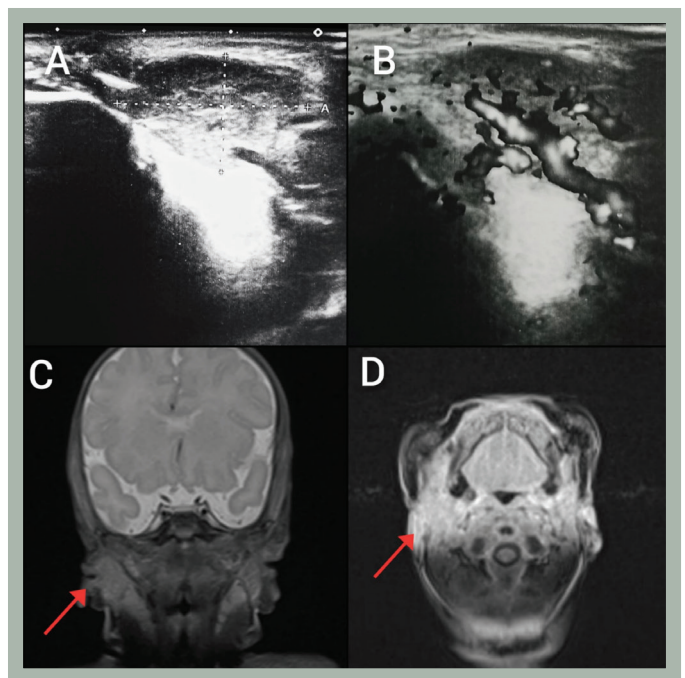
(A and B) Diffuse enlarged (22.3x13.7 mm in diameter), edematous and hypervascularized right parotid gland on ultrasound images. (C and D) Magnetic resonance images with gadolinium administration of the right parotid gland, showing enlarged gland (arrows), with no evidence of mass or abscess formation
